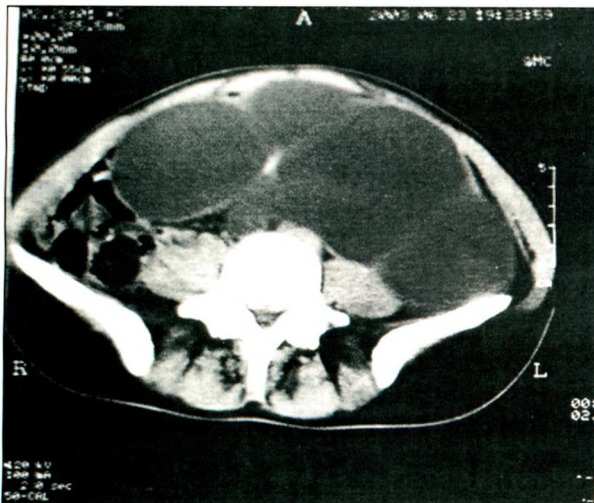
Computed tomography (CT) of the retroperitoneum showing giant hydronephrosis.
